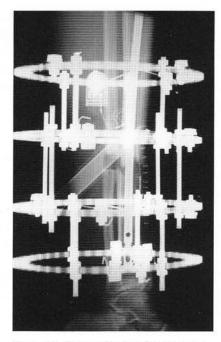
Postoperative lateral radiograph on the day of surgery.
